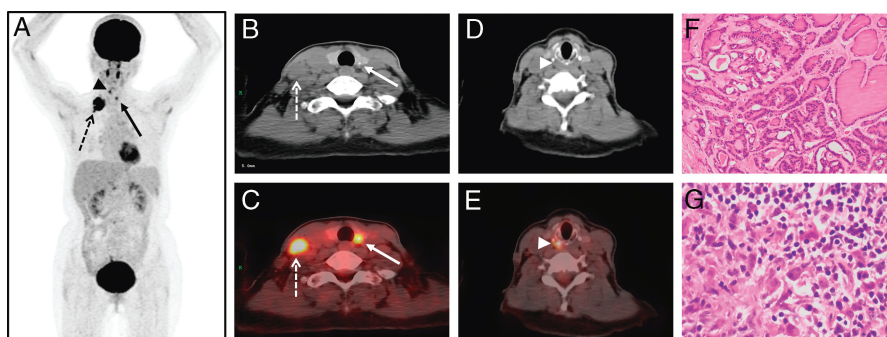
A 51-year-old woman presented with a right supraclavicular painless mass for 1 week. The ultrasonography revealed the right supraclavicular enlarged lymph nodes, which were suggestive of malignancy (images not shown). The patient refused the puncture cytology examination. ^{18}F -FDG PET/CT was then performed for clarification of the malignant supraclavicular lymph nodes. Three foci of increased activity in the neck were noted from the MIP image (A). The axial images (B, CT; C, fusion) revealed a nodule approximately 0.80 cm in diameter with SUV_{max} of 5.18 (solid arrow) in the left thyroid lobe and the right supraclavicular enlarged lymph nodes with SUV_{max} of 16.48 (dotted arrow) mimicking thyroid carcinoma with cervical lymph node metastases. In addition, a nonspecific focal activity in the posterior pharyngeal wall region (arrowhead) was supposed to be physiological uptake of muscle on the axial CT (D) and fusion (E) images. The postoperative pathology revealed the diagnosis of synchronous papillary thyroid carcinoma (F, HE, $\times 200$) and classical Hodgkin lymphoma (G, HE, $\times 400$). The synchronous double primary malignancies, especially the synchronous Hodgkin lymphoma and papillary thyroid carcinoma, are rare and usually detected incidentally.^{1–4} Both thyroid carcinoma with lymph node metastasis lesions and lymphoma lesions generally exhibit multiple uptakes of FDG, which increases the difficulty of diagnosis for lesions confined to the neck as shown in these 2 cases.^{5,6} However, the possibility of unifocal small-sized (<1 cm) papillary thyroid carcinoma with only contralateral cervical lymph node metastases is extremely unlikely.^{7,8} Therefore, when a patient with increased FDG uptake in a small thyroid nodule and in contralateral cervical enlarged lymph nodes, even without abnormal findings in other locations, the possibility of the rare synchronous lymphoma and papillary thyroid carcinoma should be considered.
